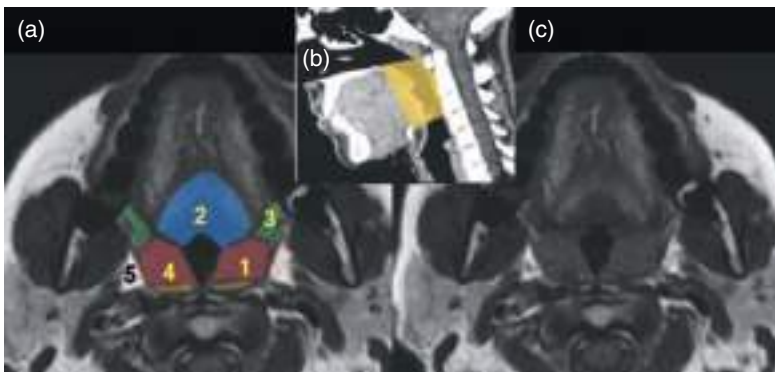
Oropharynx. Axial T1-weighted MRI at the level highlighted in yellow. 1, palatine tonsil; 2, base of the tongue; 3, anterior tonsillar pillar (palatoglossus muscle); 4, posterior tonsillar pillar (palatopharyngeal muscle); 5, parapharyngeal space.
